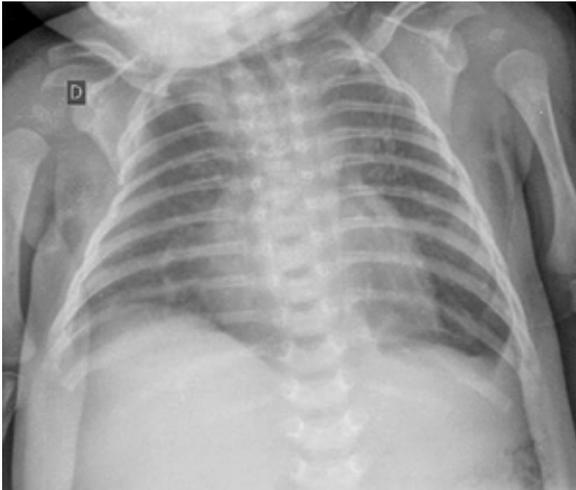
Thorax X-ray in AP after surgical correction of the diaphragmatic hernia with no apparent abnormalities.
